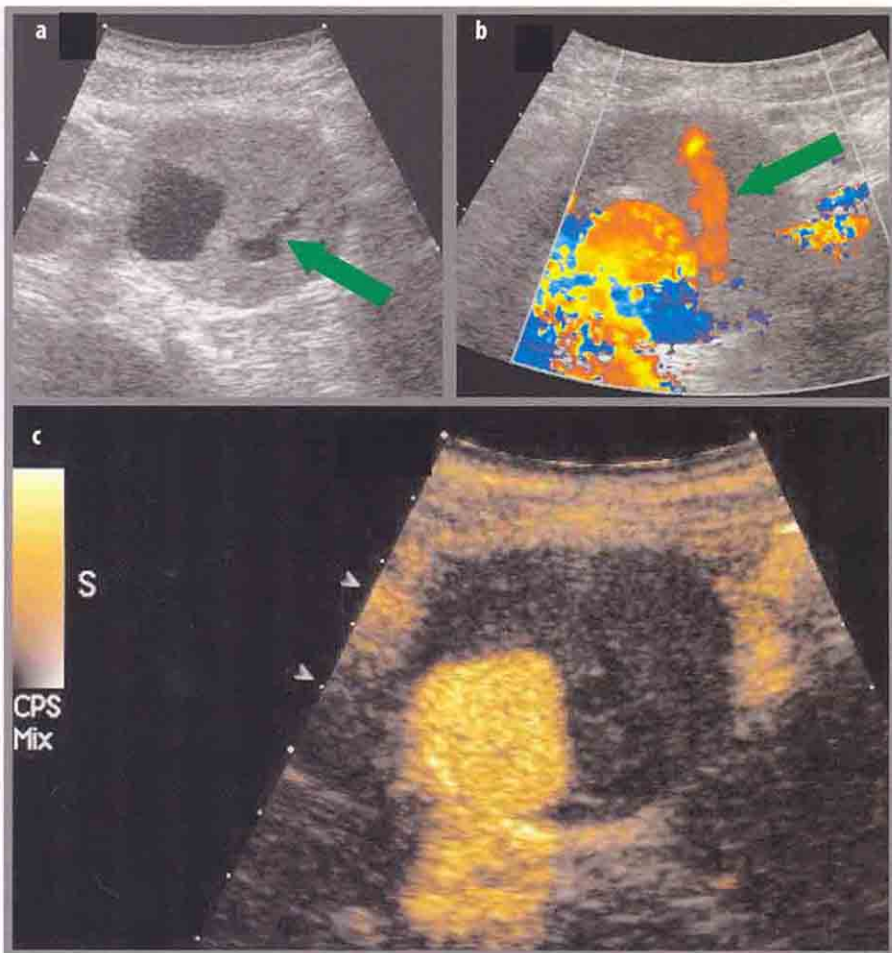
AAA surrounded by a parietal layered thrombus, not supplied with blood. a Transversal scan, B-mode. An AAA with homogeneous peripheral thrombus with a layered anechoic appearance (green arrow) is detected; the true lumen is located laterally, on the right. b Transversal scan, colour Doppler. A chromatic signal is detectable both inside the residual lumen and in the anechoic layer of the thrombus (in red), potentially supplying inflow (green arrow). c Transversal scan, CEUS. The aortic lumen is enhanced; inside the thrombus and its anechoic portion no signal of contrast agent is demonstrable
